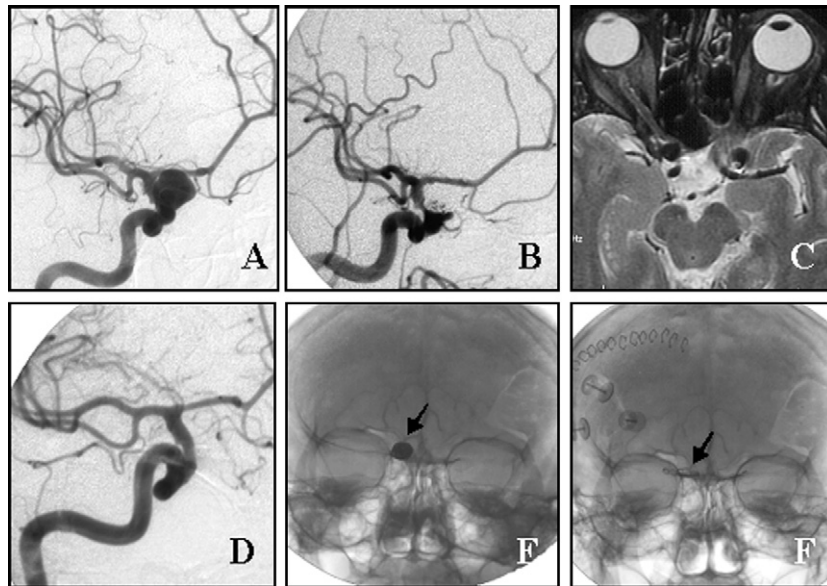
(A) Diagnostic arteriogram revealing a right ophthalmic artery aneurysm. (B) Twenty-two month after embolization, patient developed decreased right visual acuity. Two-year post-coiling arteriogram demonstrating 90% occlusion of aneurysm. (C) Preoperative MRI showing the compressed right optic nerve by the coils ball. (D) Postoperative arteriogram demonstrating complete obliteration of aneurysm. (E and F) Pre- and post-operative skull X-ray showing the position of packing coils and the position of clips after coil removal, respectively (arrows).
